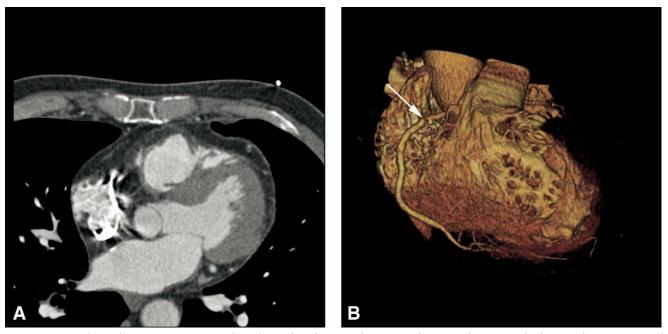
Contrast-enhanced CT coronary angiography without saline chasing technique. Display as axial MIP (A) and volume rendering (B). A streak artifact emanating from dense contrast material in the right heart overlies the right coronary artery (A) and causes artifactual stenosis of the proximal right coronary artery in the volume rendering. (Color version of figure is available online.)
